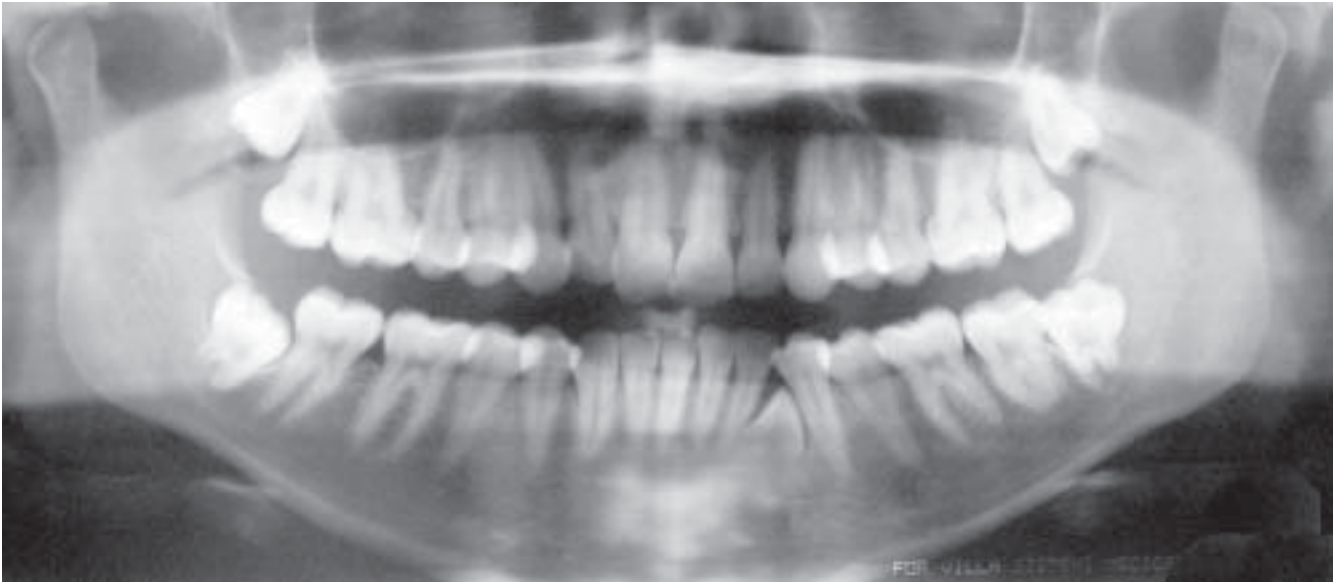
Panoramic radiograph of twin 1
